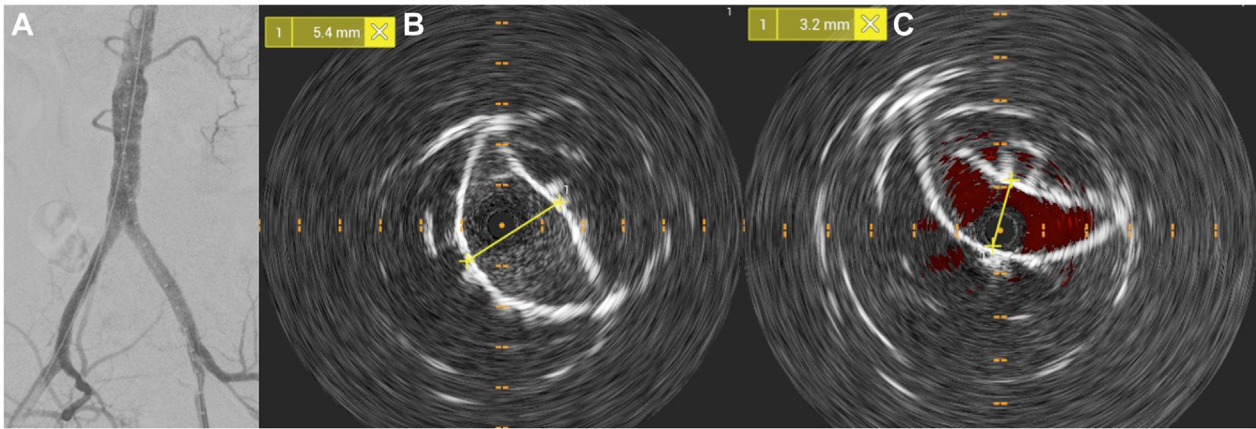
A, Completion digital subtraction angiography (DSA) after covered endovascular reconstruction of the aortic bifurcation (CERAB), showing patency of the treated segment without evidence of any residual defect. B, Intravascular ultrasound (IVUS) of the right iliac axis of the same case, showing adequate D-shape and expansion of the right kissing stent (KS) (minor axis diameter: 5.4 mm). C, IVUS of the left iliac axis of the same case, showing compression and inadequate expansion of the left KS (minor axis diameter: 3.2 mm).
